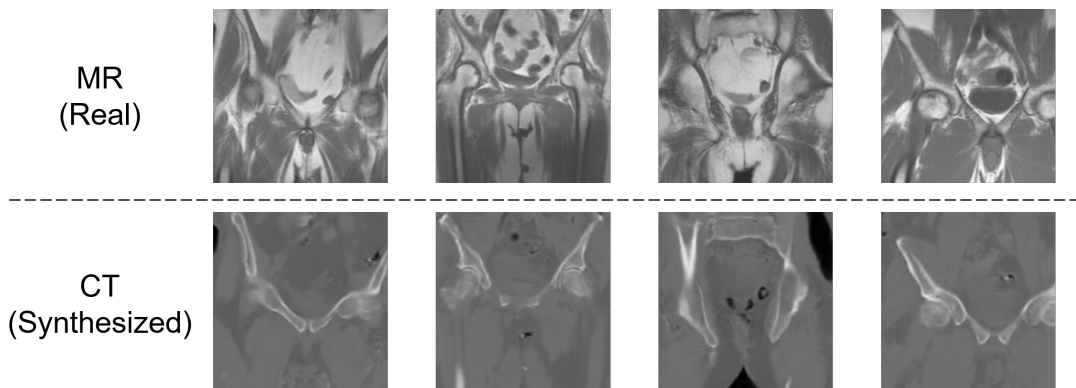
CycleGAN CT generator ( $G_{CT}$ ) training results (training size: 4000, with implementation of structural consistency loss  $\mathcal{L}_{str}$ )
